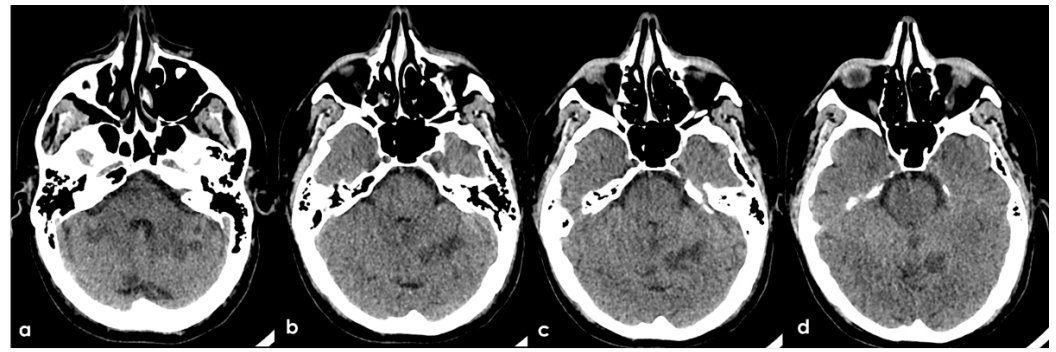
Brain CT performed at the admittance to the ED. From a to d ascending axial CT slices of the posterior cranial fossa, showing bilateral subcortical multiple rounded hypodensities in the cerebellar white matter (a) in PICA territory with left side prevalence (b, c) and a similar hyperintense lesion in the superior part of vermis (b-d) and in the left anterior lobe of the cerebellum, supplied by the superior cerebellar artery (SCA).
